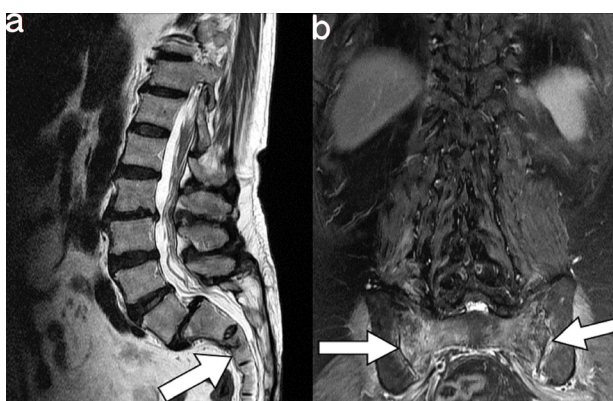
MRI (a, T2-weighted sagittal view; and b, T2-weighted coronal view) of an 74-year-old woman with sacral insufficiency fracture. SIF involve S2 body level (white arrow) and bilateral alar area. MRI = magnetic resonance imaging, SIFs = sacral insufficiency fractures.
